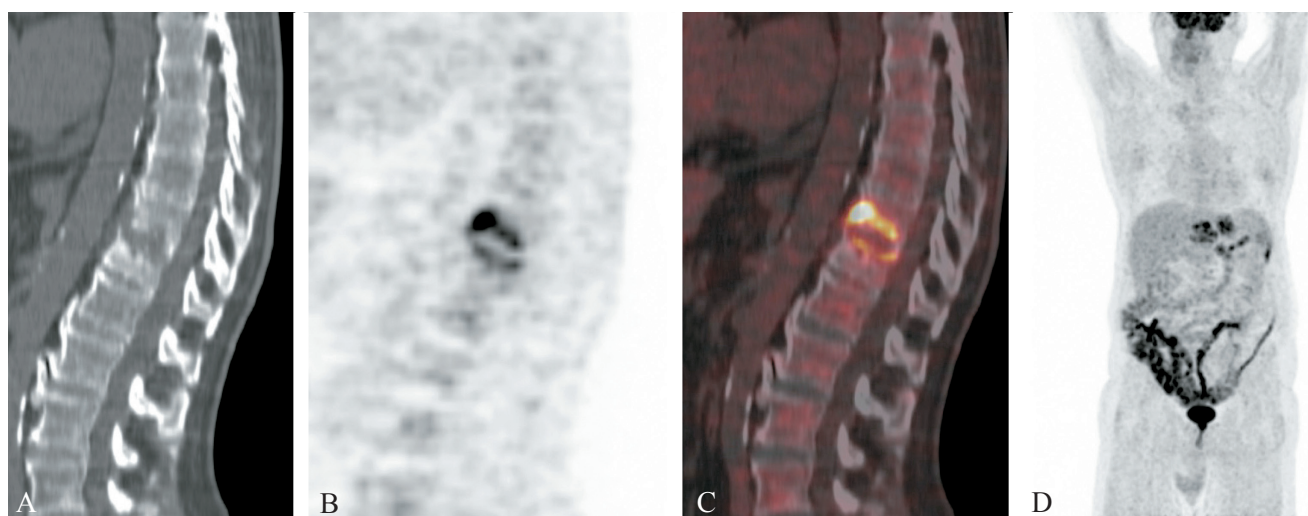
^{18}F FDG PET/CT imaging in a 48 years old patient with back pain, fever and *S. epidermidis* infection of the lumbar spine confirmed by positive microbiology culture of the vertebral biopsy. Sagittal CT (A); PET (B); fused images (C) and MIP (D) showed spondylodiscitis with bone destruction between T11 and T12.
